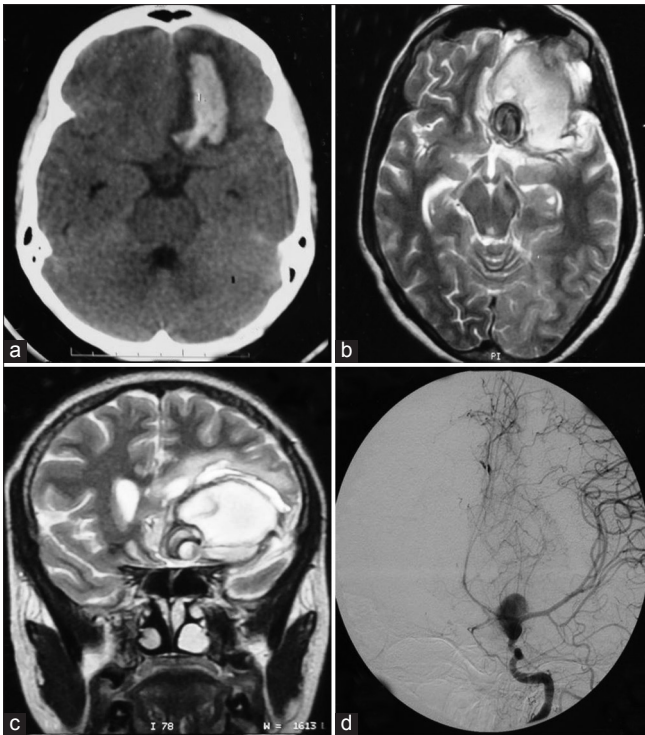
(a) CT showing left frontal hematoma; (b) and (c) Axial and coronal T2 MRI showing hematoma and suspected aneurysm; (d) DSA showing supraclinoid aneurysm
